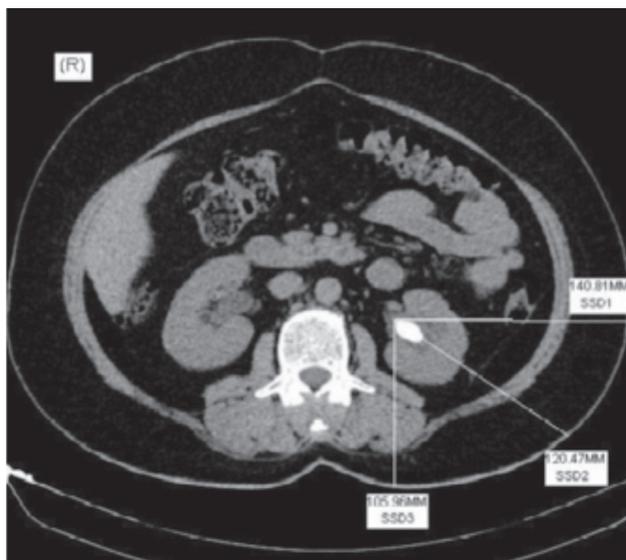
Skine-to-stone distance measurement on axial plane computed tomography imaging
